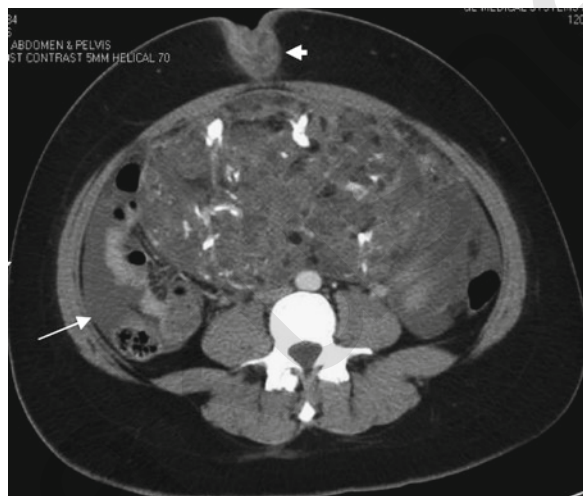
CT: large Immature teratoma with foci of fat, calcification, solid tissue, ascites (*arrow*) and malignant umbilical nodule (*arrowhead*)
